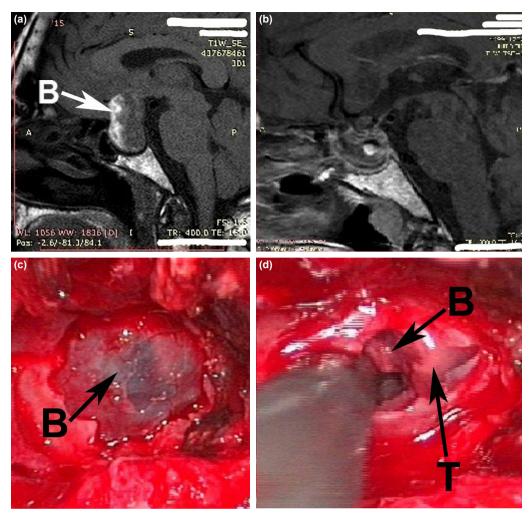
A 40-years old female patient presented with pituitary apoplexy. Pre-operative T1-sagittal non-contrast magnetic resonance imaging (MRI) slice shows blood within the tumor (a). Post-operative T1-sagittal MRI slice shows total resection of pituitary adenoma (b). Intraoperative endoscopic view before the dural opening shows the black shadow of blood products in the sellar region (c). After the dural opening tumor tissues with blood products are visible in black color (d). B: Blood; T: Tumor.
